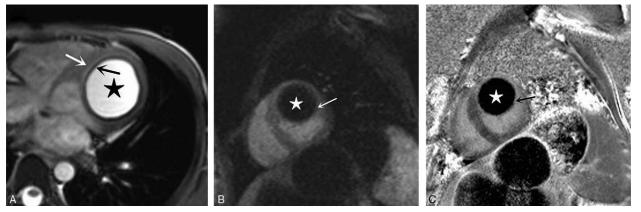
Cardiac magnetic resonance imaging shows the imaging features of the left ventricular echinococcosis (asterisk). (A) A cystic lesion with liquid content and visible cyst wall with "double line sign" (black and white arrows); (B, C) Two chamber view of left ventricle depicts the cyst wall with early contrast enhancement and minimal late gadolinium enhancement (arrow).
